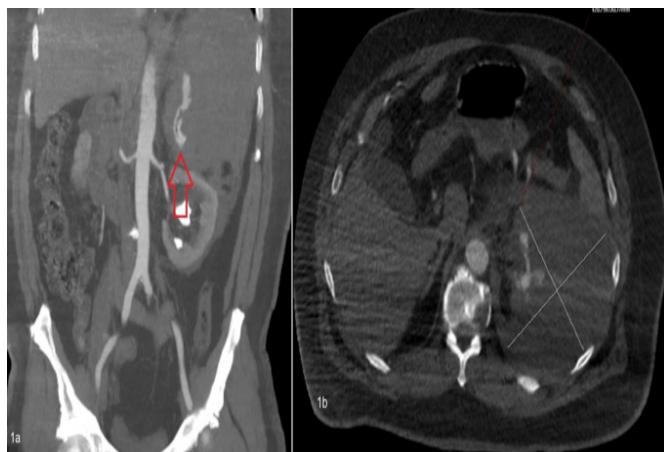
Red arrow: Abdominal aorta CT angiography showing active contrast extravasation 1b. The dimensions of the intra-abdominal hematoma due to splenic artery aneurysm rupture
